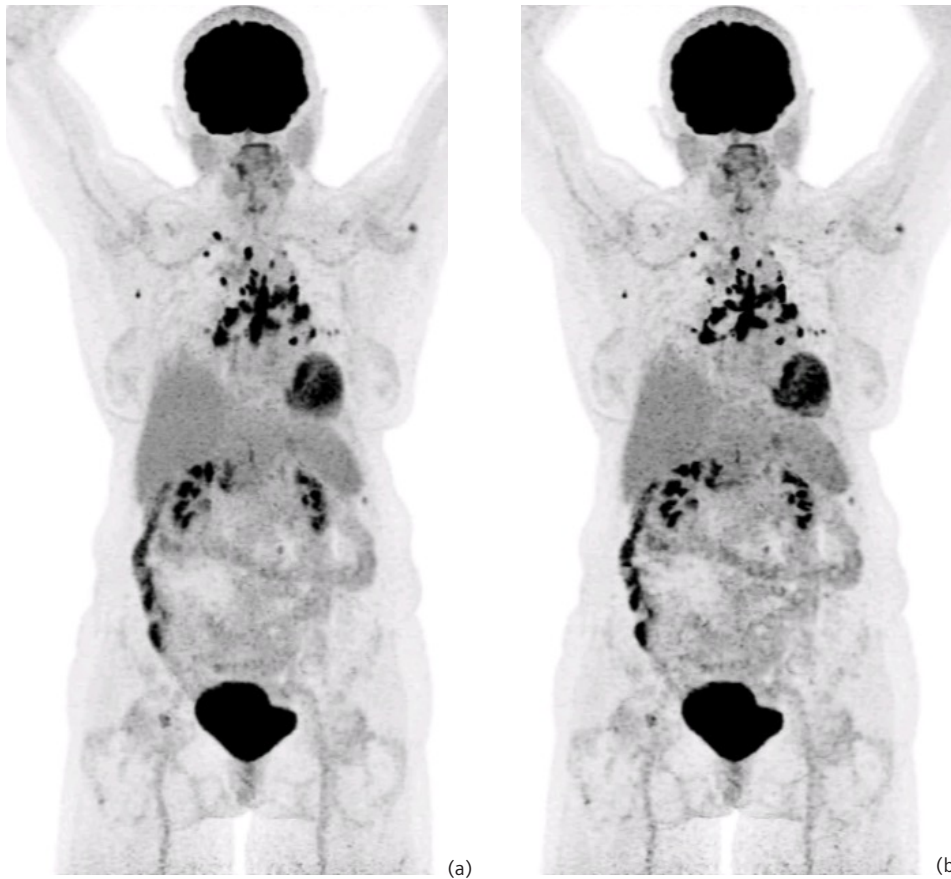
Comparison of static MIP and OncoFreeze MIP. Data courtesy of University Medical Center Groningen, Groningen, The Netherlands. Injected dose: 5.1 mCi (190 MBq), ¹⁸F-FDG; Scan acquisition: 440 x 440 matrix, PSF + TOF 4i5s, 0.8 mm/sec FlowMotion continuous bed motion.
